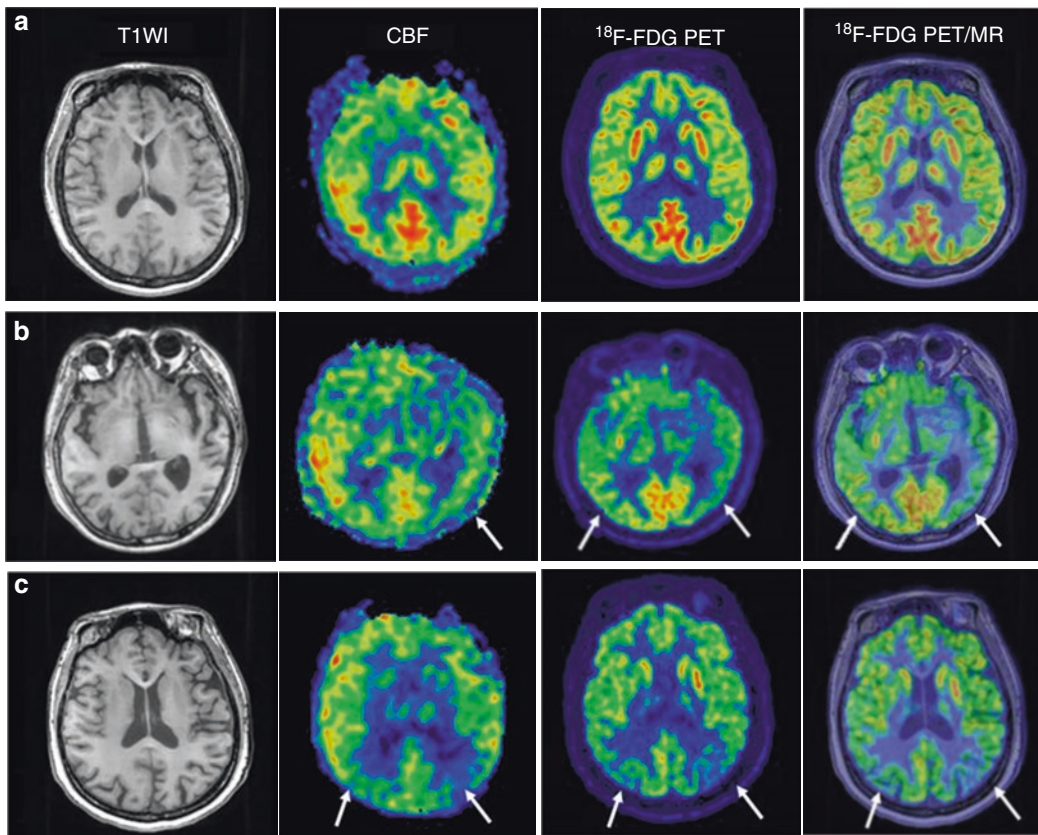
A cognitively normal, 67-year-old, healthy female subject underwent integrated ^{18}F -FDG PET/MR; T1WI shows no significant atrophy in brain structures; CBF imaging shows no abnormal reductions in CBF; and ^{18}F -FDG PET shows no abnormal ^{18}F -FDG uptake (a). A 69-year-old male patient with MCI; T1WI shows enlargement of the left posterior horn of the lateral ventricle; CBF
